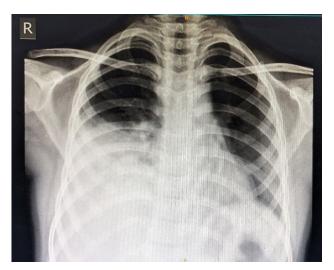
Chest xray taken on day 1 of admission
